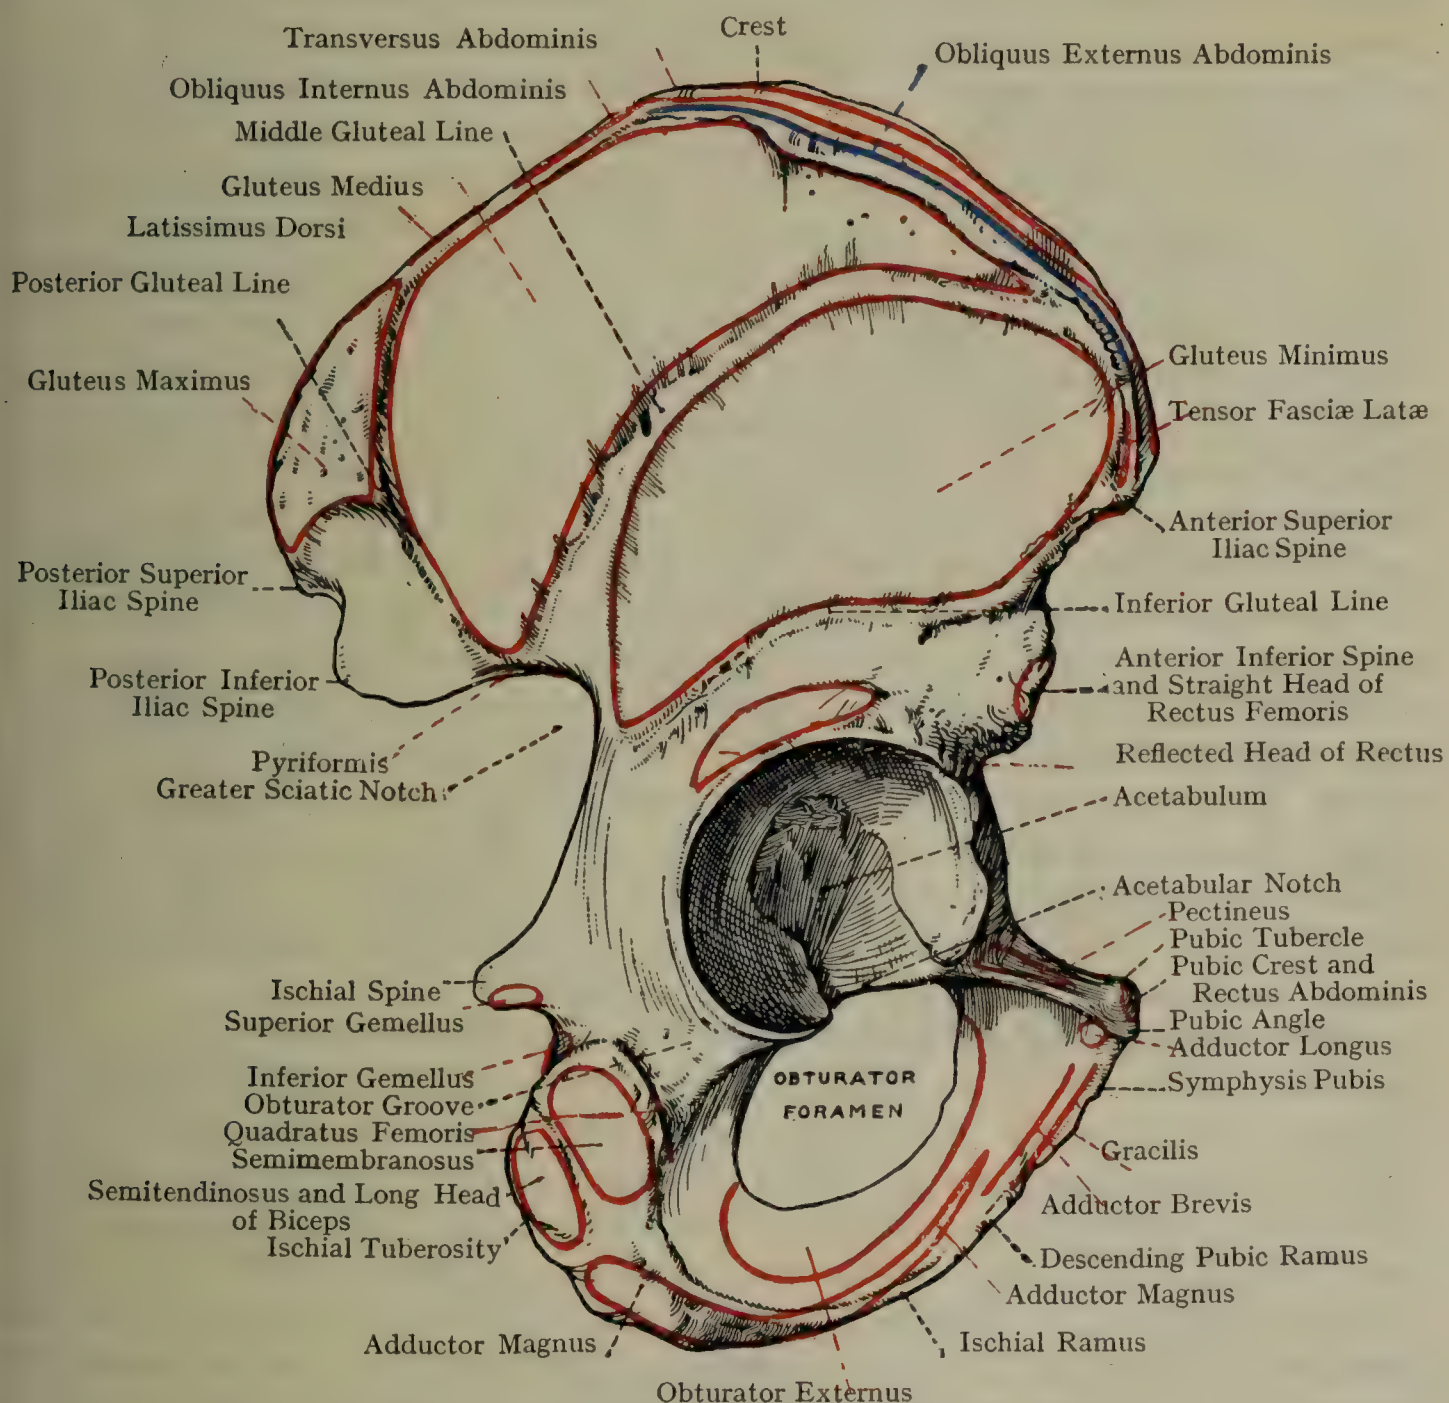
THE RIGHT HIP BONE (LATERAL ASPECT).
